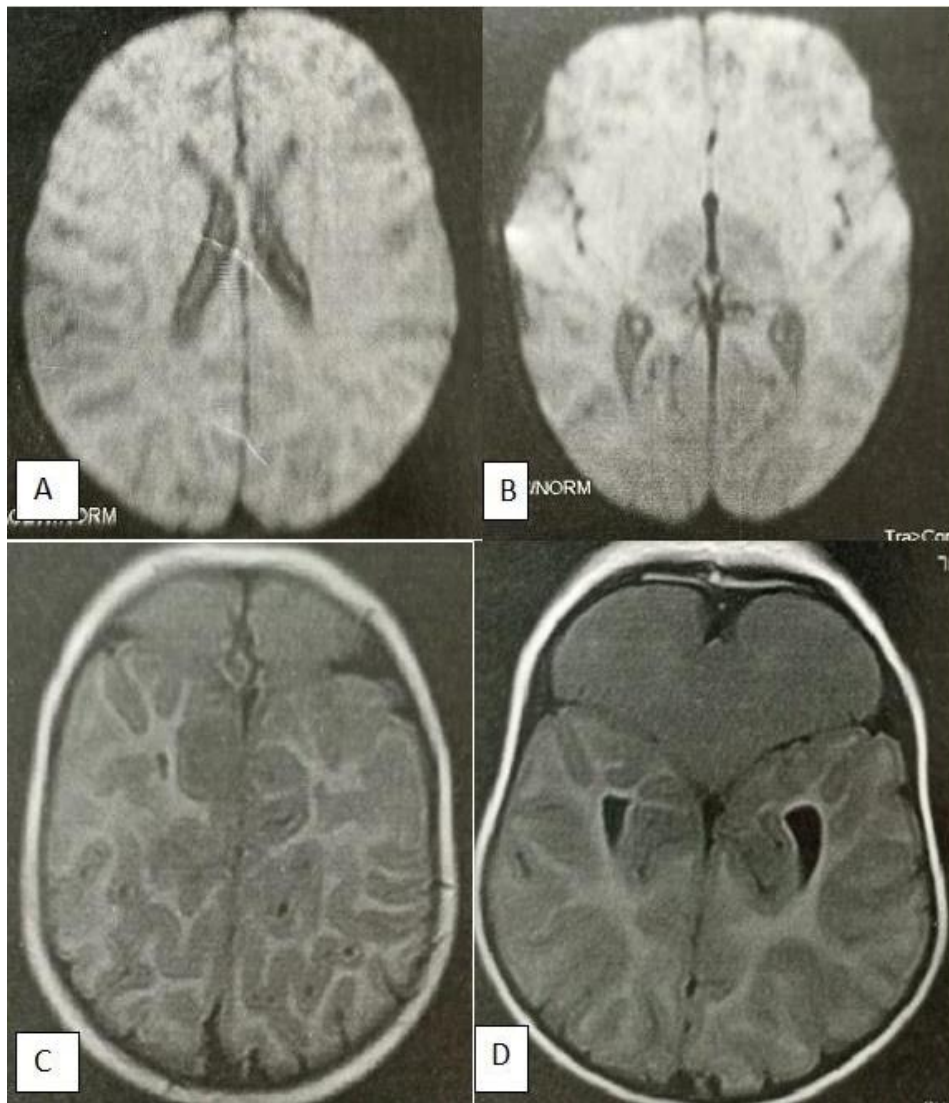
Cerebral T2-weighted and Flair MRI images depicting hypersignal of the lenticular and caudate nuclei (A, B) and delayed myelination of the white matter (C, D)
